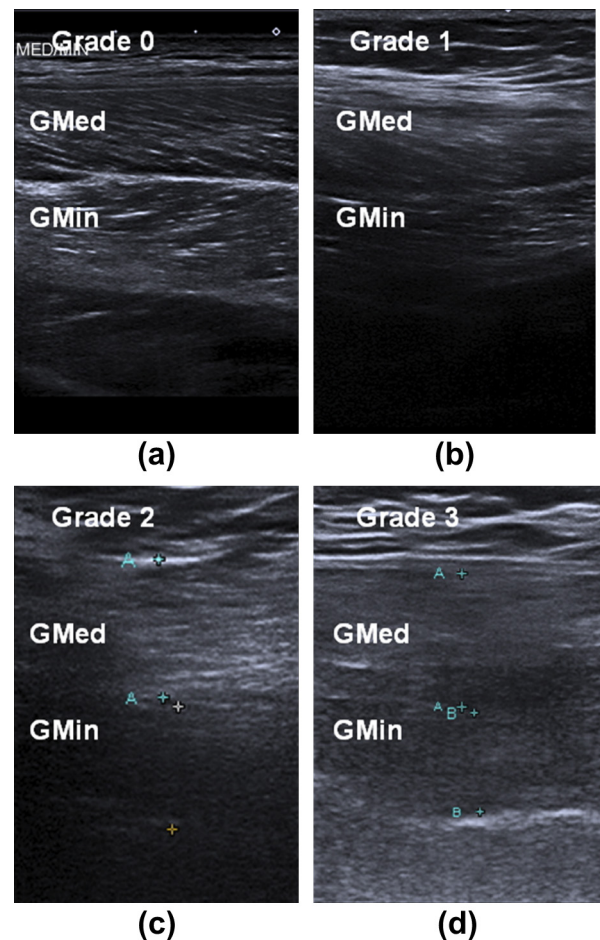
Ultrasound grading of hip abductor muscle atrophy (cranial aspect to left of the images). Lateral longitudinal images of the midpoint position of the gluteus medius and minimus muscles showing consecutive graded muscle atrophy as (a) grade 0 or normal muscular architecture without fatty replacement; (b) grade 1 <30% size reduction with some fatty replacement; (c) grade 2 or 30–70% size reduction with fatty replacement; and (d) grade 3 or extensive loss of muscular architecture with widespread fatty replacement and a decrease of >70% in size as compared to the contralateral hip muscles. GMed, gluteus medius muscle; GMin, gluteus minimus muscle.
